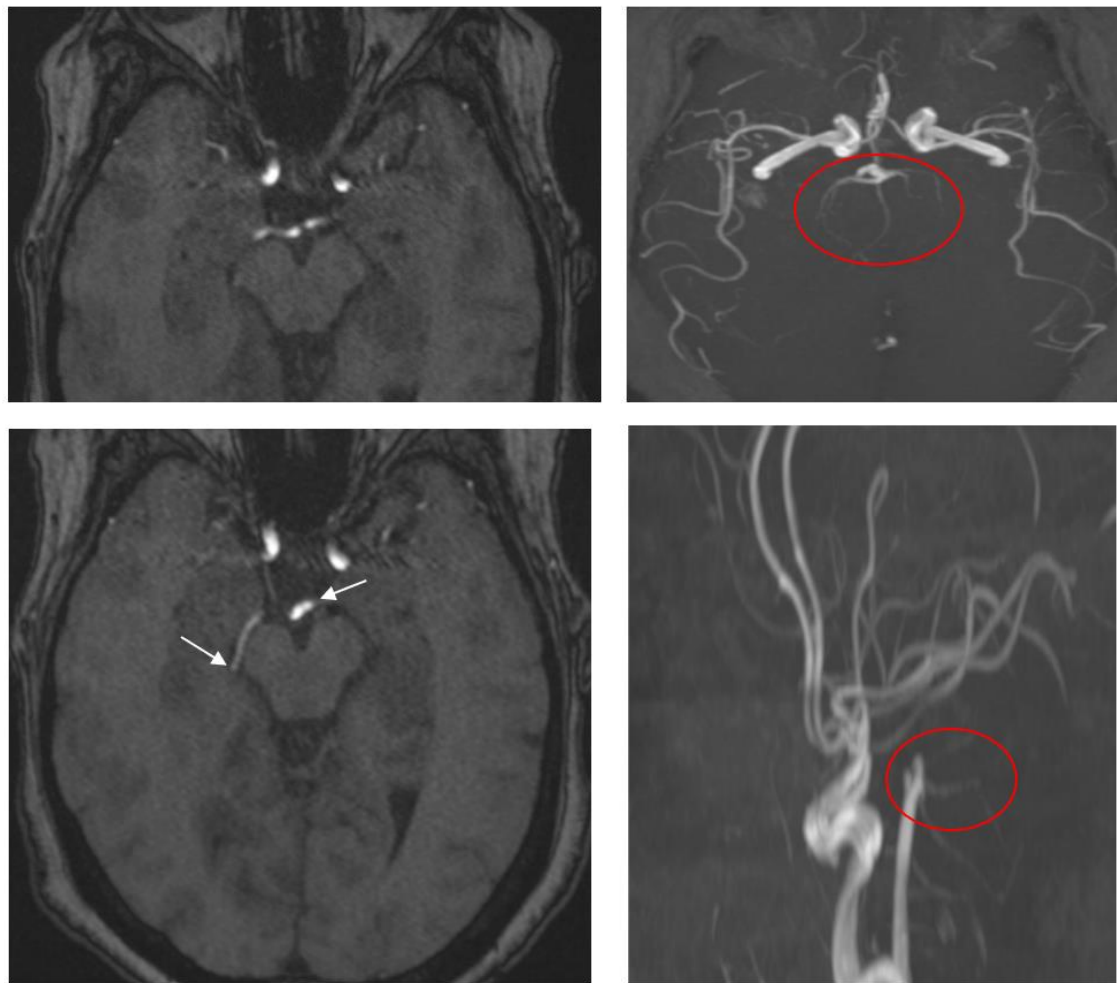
MRI-angiography (A to D) showing occlusion of posterior cerebral arteries (arrows and circle)
